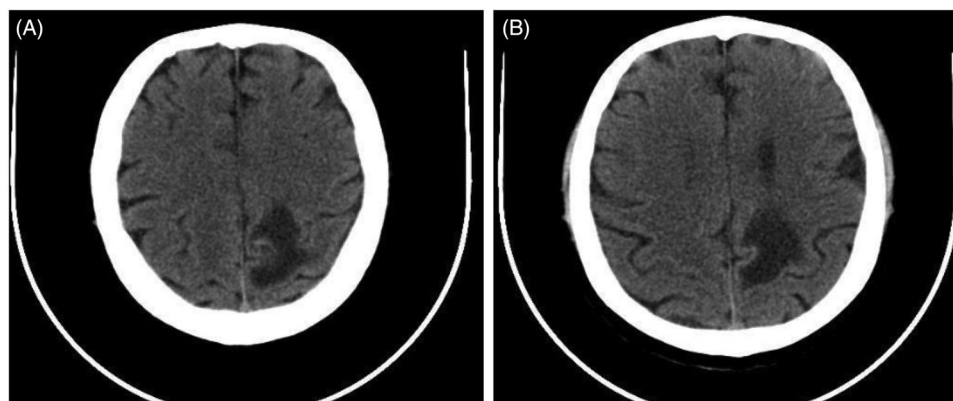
Cranial CT 20 months after Cyberknife radiosurgery and 3 months of bevacizumab treatment.
